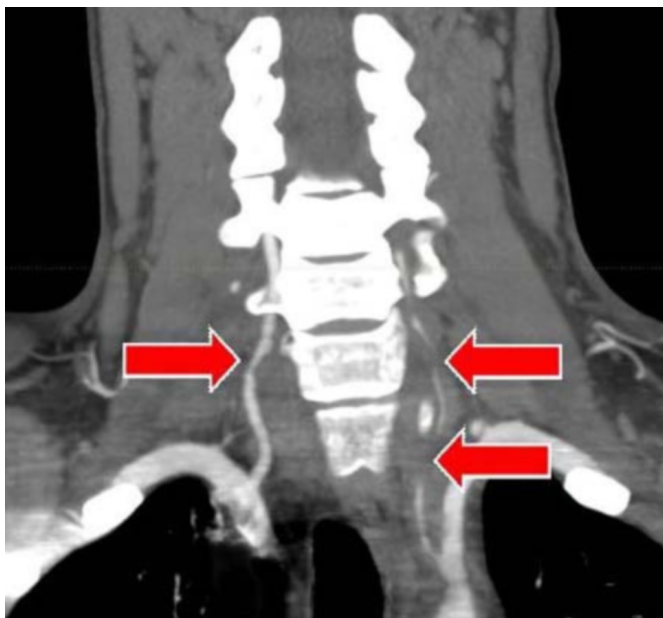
Coronal CT with contrast, demonstrating multiple sites of stenosis in left and right vertebral arteries.
